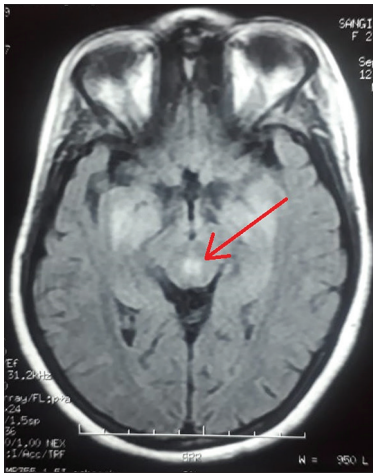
Cerebral MRI showing FLAIR hyperintensity of the peri-aqueductal region (red arrow) which is highly specific for WE
